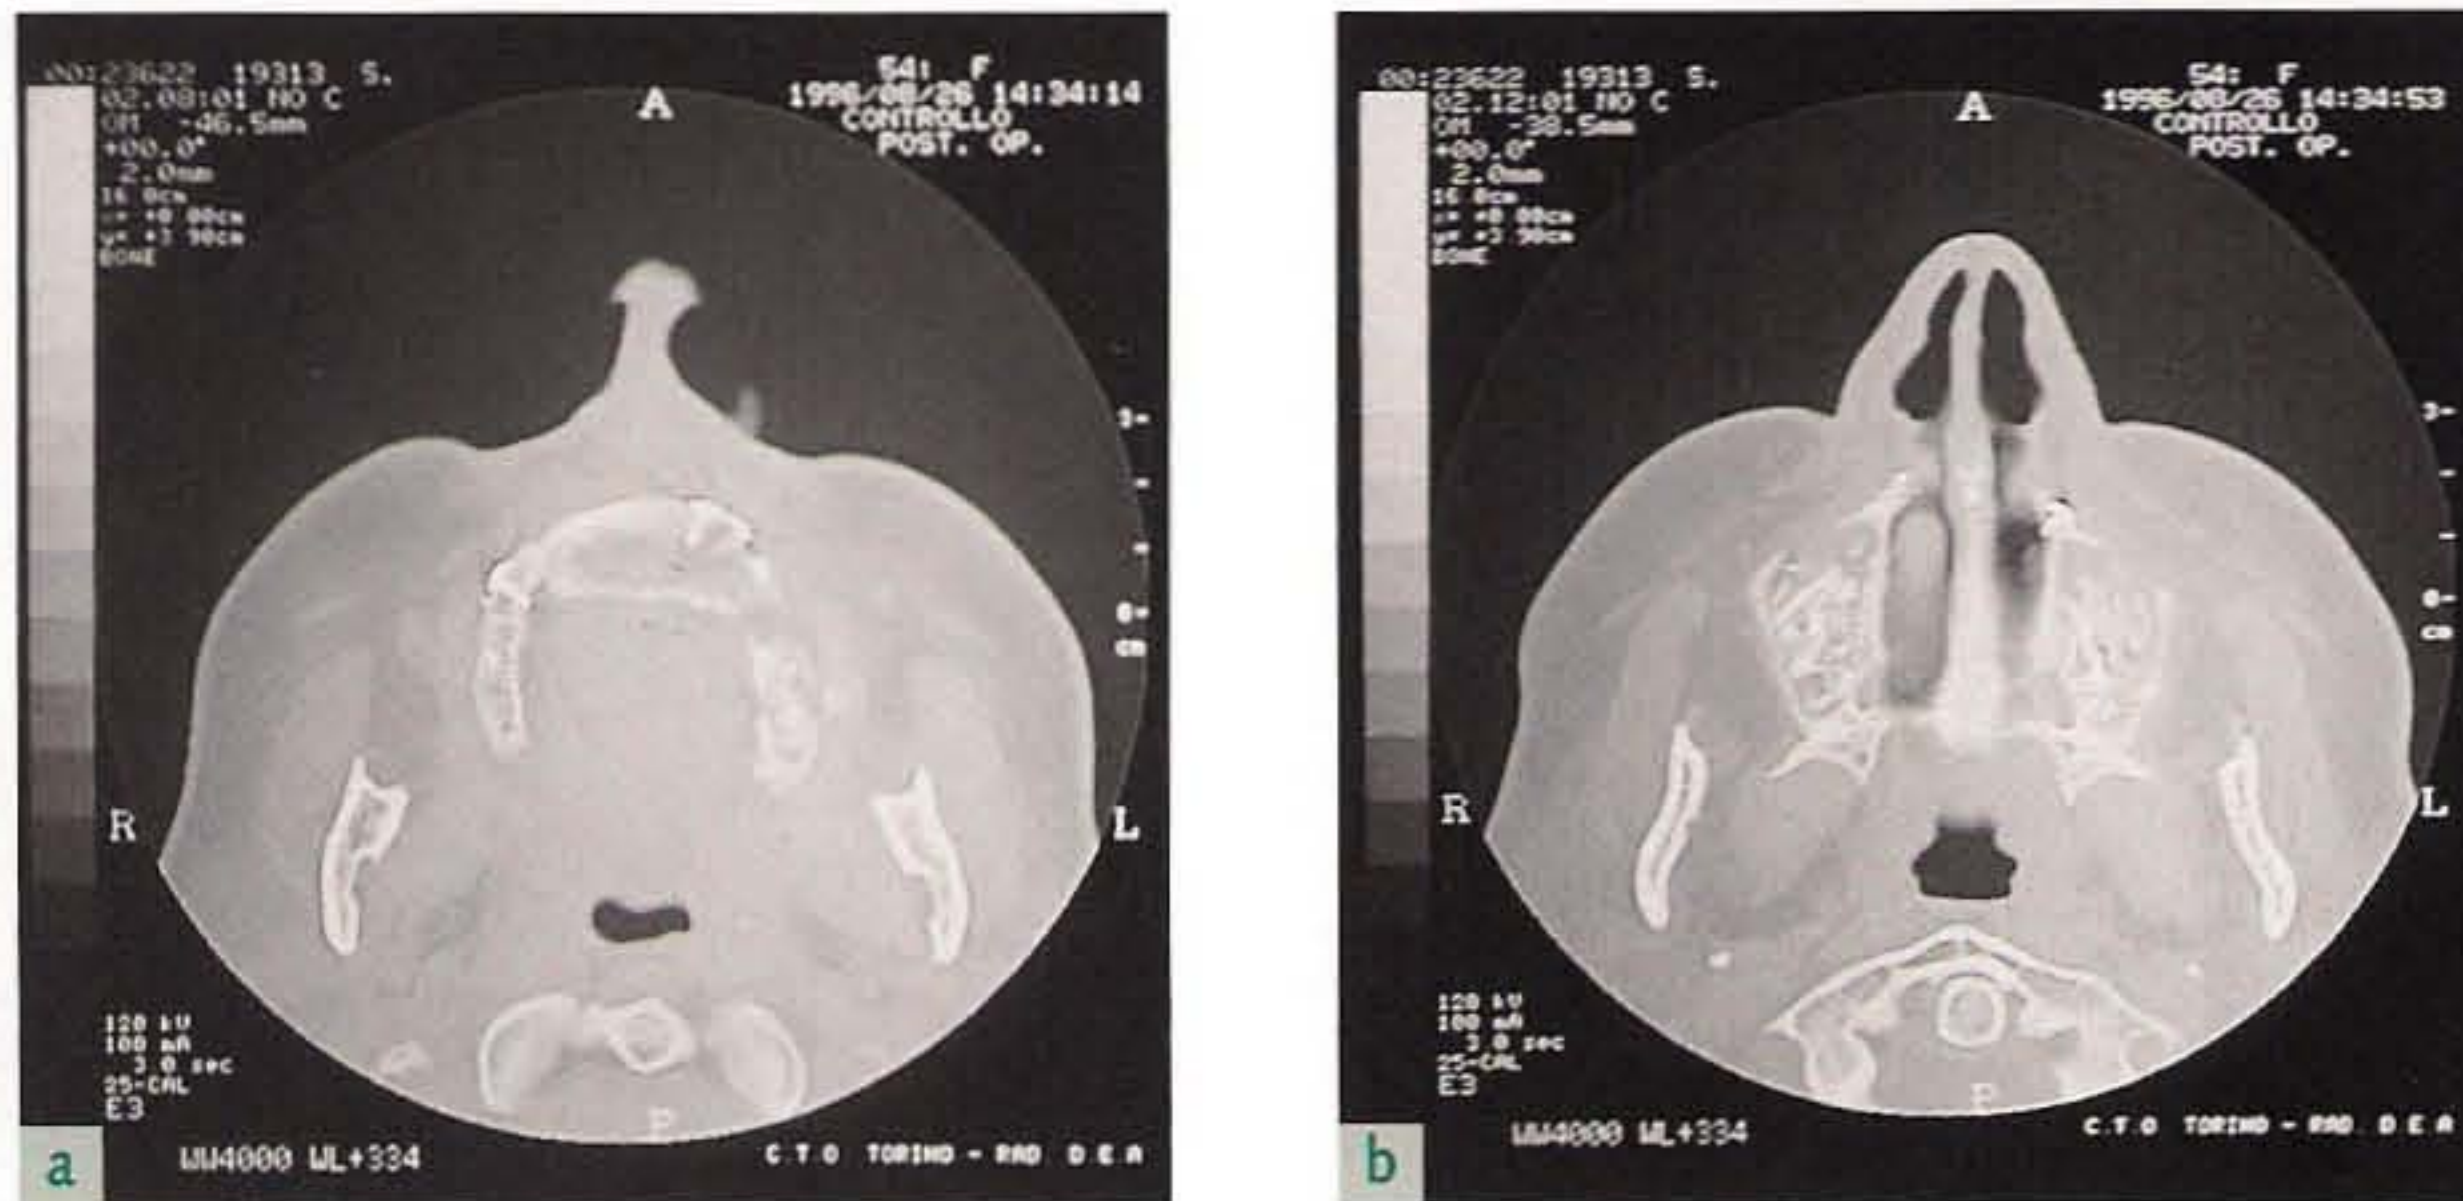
Postsurgical CT scans reveal both (a) the well-stabilized anterior onlay and (b) the bilateral sinus elevation with a particulate bone graft taken from the iliac crest.
